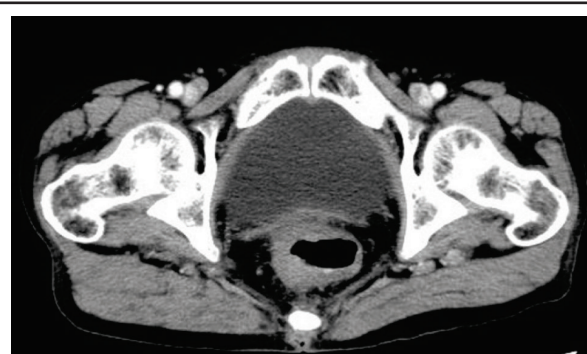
Contrast-enhanced computed tomography of the abdomen (axial section) shows asymmetric thickening of the wall of the rectum; no perirectal lymph nodes are seen.
